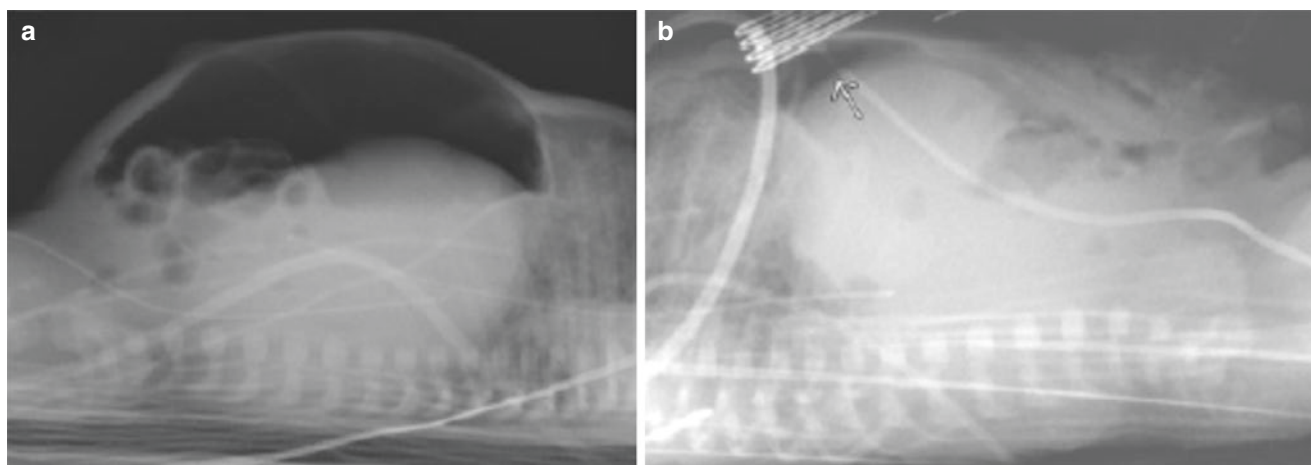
(a, b) Cross-table lateral radiographs show anteriorly placed pneumoperitoneum (*arrow*)
